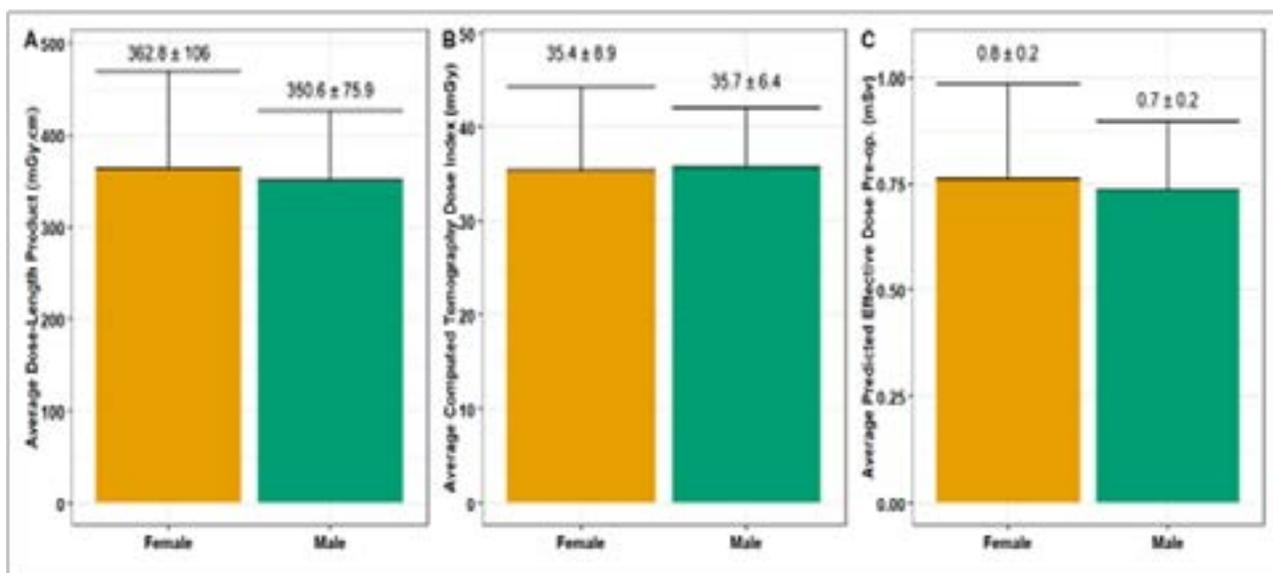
Relationship between patients’ gender and radiation parameters; A: for Average Dose-Length Product (DLP); B: for Average Computed Tomography Dose Index (CTDI); and C: for Average Predicted Effective Dose Pre-operative (mSv); with error bars representing the standard deviations.
